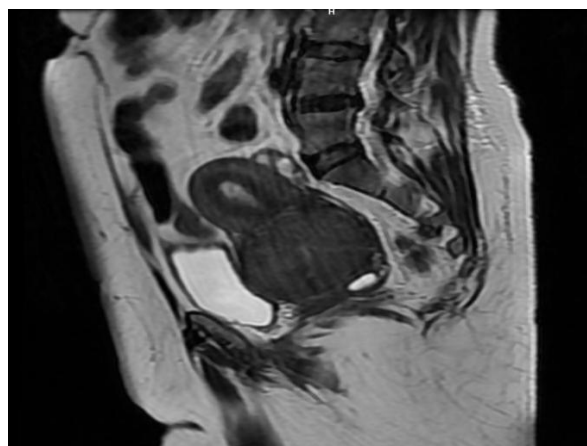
Cervical leiomyoma MRI
